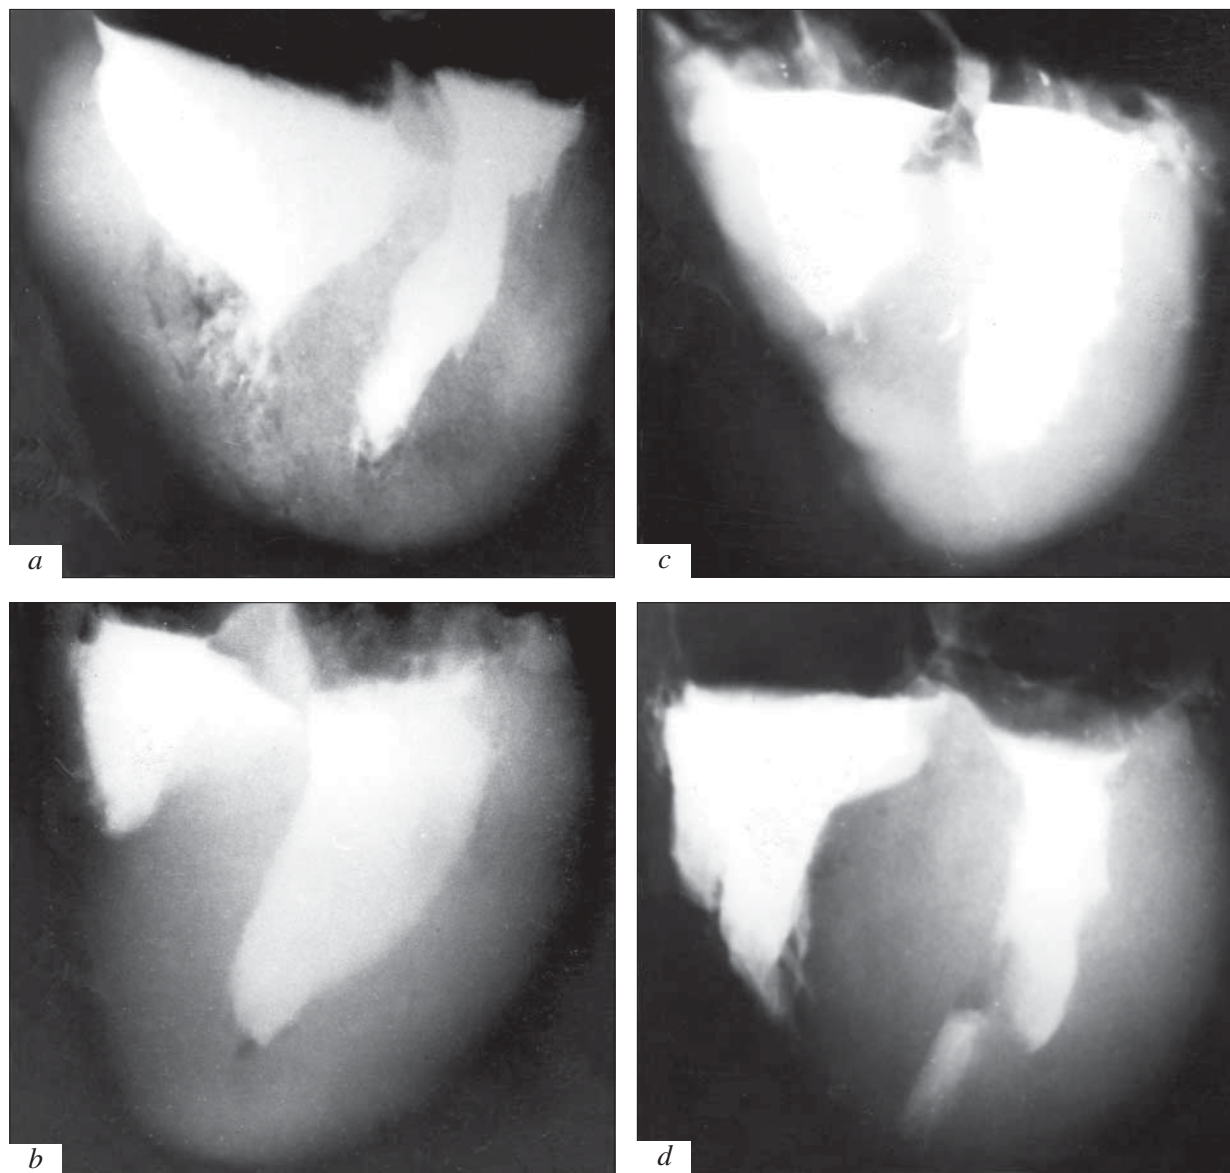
Variants of midventricular hypertrophy (obstruction) of interventricular septum (IVS) during hypertrophic cardiomyopathy. Postmortem contrast cardioventriculography. *a*) midleft ventricular variant with pronounced midventricular hypertrophy of IVS and left ventricular wall accompanied by marked shrinkage of deformed ventricular cavity and preserved volume of the right ventricle, patient V., 40 years; *b*) midright ventricular variant with marked midventricular hypertrophy of IVS, which surpassed the thickness of the left ventricular wall and decreased free cavity of the right ventricle, patient K., 46 years; *c*) midproximal variant with asymmetric hypertrophy of IVS and its turn at valve rings, which curved long-shaped left ventricle, patient A., 44 years; *d*) midmaximal variant with pronounced hypertrophy of IVS; thickness of IVS 2-fold surpassed thickness of the left ventricular wall, while volume of the left ventricle was 2-fold lower than that of the right ventricle, patient G. (48 years). Here and in Figs. 2 and 3: 3-fold demagnification from original x-ray films.
